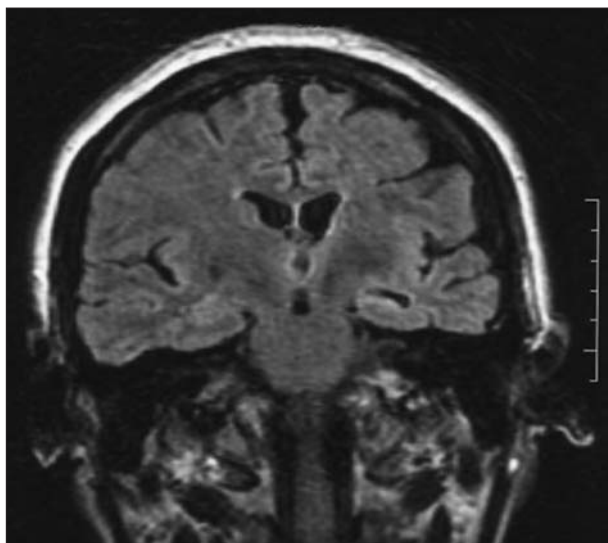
Axial sections of MR of the brain showing left hippocampal atrophy (FLAIR).
